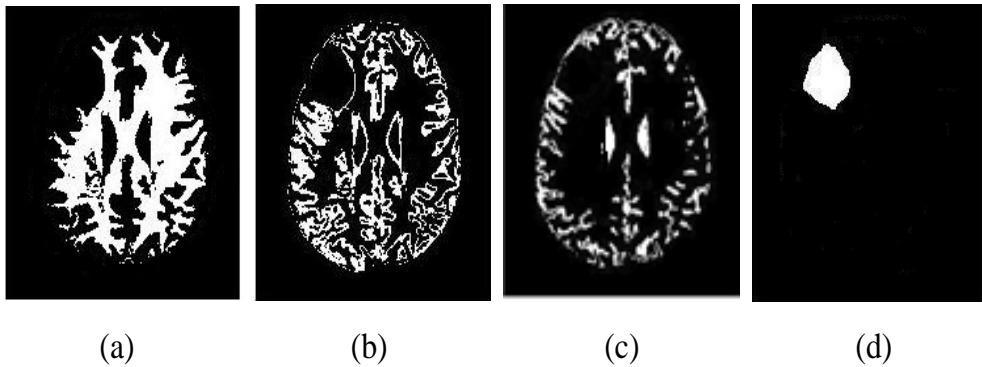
Clusters of Brain in T2-weighted MRI Image: (a) White Matter (b) Gray Matter (c) Cerebrospinal Fluid (d) Abnormal Region
